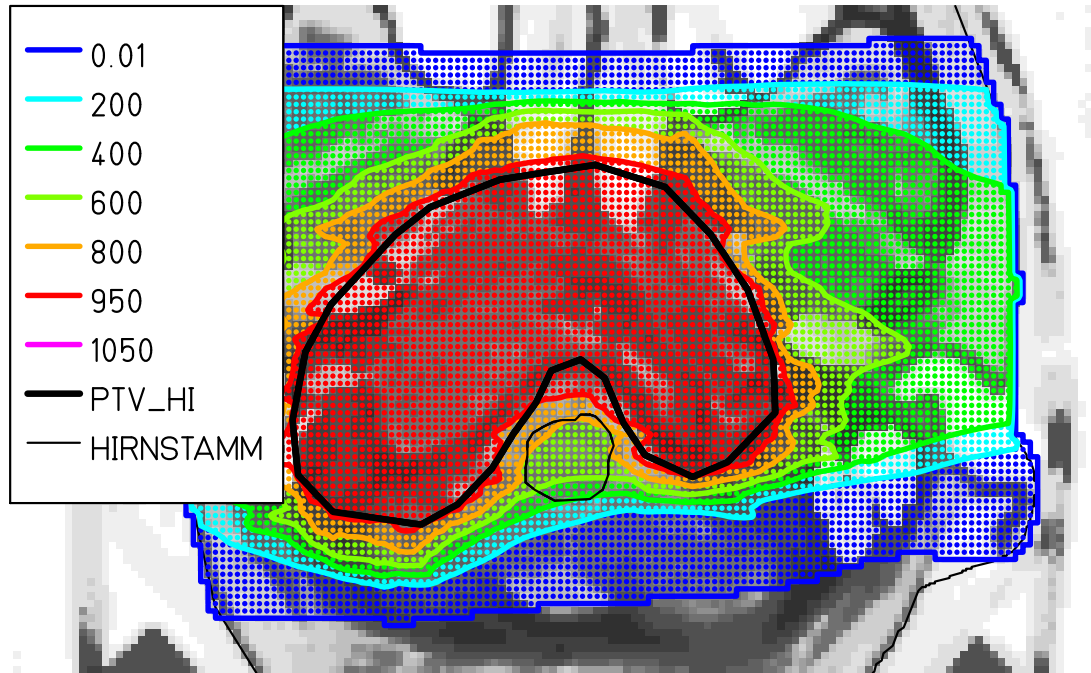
Optimized biological dose distribution generated by two opposing fields entering from the left and right hand side, respectively. The central two-dimensional slice of the CT image is shown with the biological dose distribution overlaid. The colours correspond to the dose levels listed in the insert, given in permille of the prescribed biological dose in the tumour volume, which was 3 Gy. Although the brain tumour wraps around the critical organ (brain stem), the latter could largely be spared.
